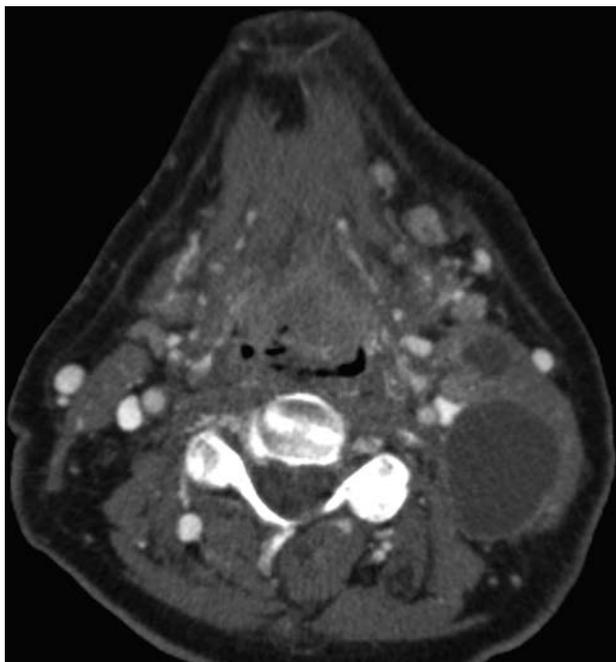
Axial contrast-enhanced CT in a 69-year-old man demonstrates a heterogeneously enlarged lingual tonsil filling the valleculae and at least 2 left cystic cervical nodes. No right neck adenopathy was evident. Biopsy of the primary site revealed p16(+) OPSCC. This was staged as cT2N2b, stage IVA OPSCC. In the eighth edition of the AJCC, the T-category does not change; however, multiple ipsilateral nodes are now assigned N1 category if < 6 cm in greatest diameter. In the eighth edition, T2N1 p16(+) OPSCC is designated stage I disease.
